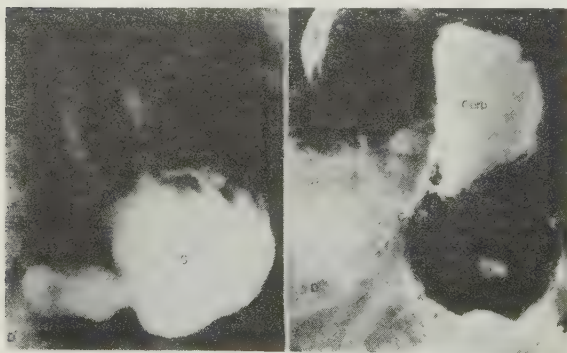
Left, upper gastrointestinal barium contrast study showing a pure paraesophageal hernia in a patient in whom a mixed paraesophageal and sliding hiatal hernia subsequently developed. Right, a similar roentgenogram taken 6 years later. C = cardia; Corp = body of stomach; D = duodenum; E = esophagus; F = fundus of stomach; H = paraesophageal hernia; S = stomach.
